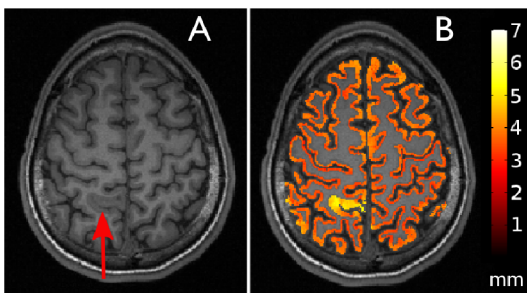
A. Axial slice of epilepsy subject with lesion indicated by red arrow. B. Cortical thickness map overlaid on structural MRI. Regions of high thickness are "hotter".
